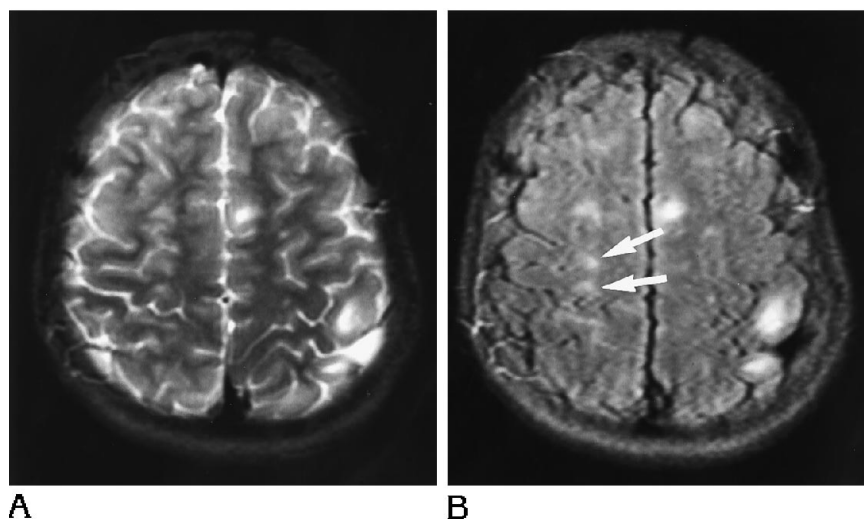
A and B, Small tubers detectable on FLAIR images (7000/160; inversion time, 2000) of patient 3 (arrows) could not be differentiated from normal gray matter on T2-weighted images (3000/100).
